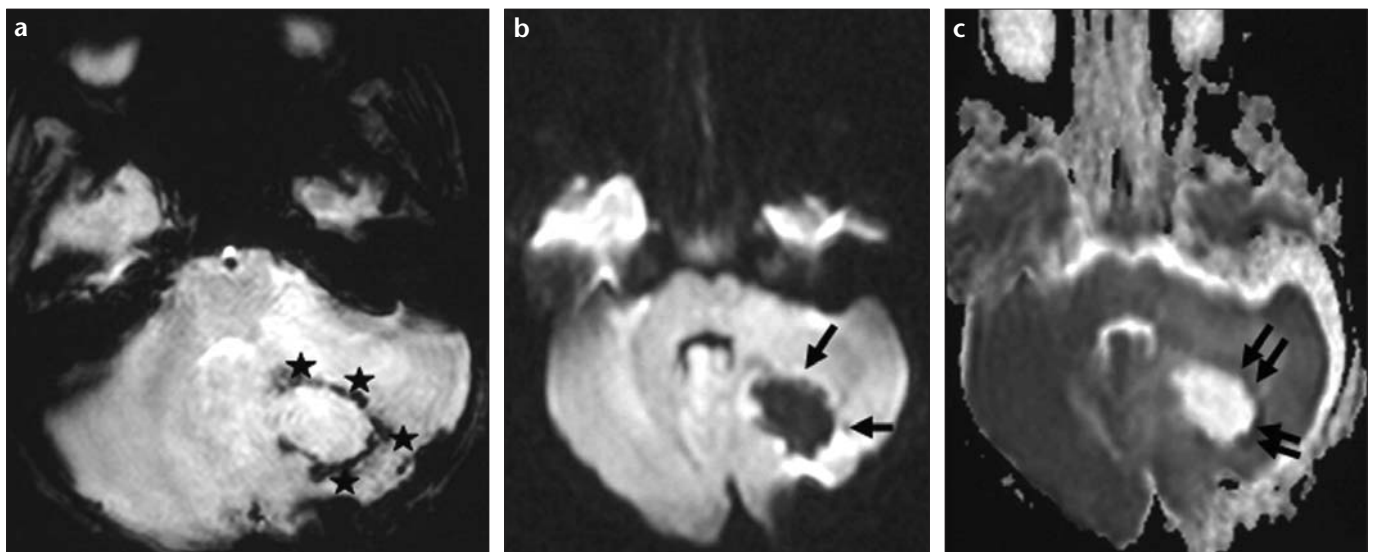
a-c. Case 5. A 3-year-old male. Early postoperative transverse T2* weighted image (a) diffusion-weighted image (DWI) (b), and ADC (apparent diffusion coefficient) map (c) of a pilocytic astrocytoma. Mixed deoxy- and methemoglobin encircling the resection cavity (stars) is seen on transverse T2*GRE image (a). Thus, restricted diffusion with high intensity on DWI (individual arrows, b) and low value on ADC map (double arrows, c) is the result of hemorrhage.
